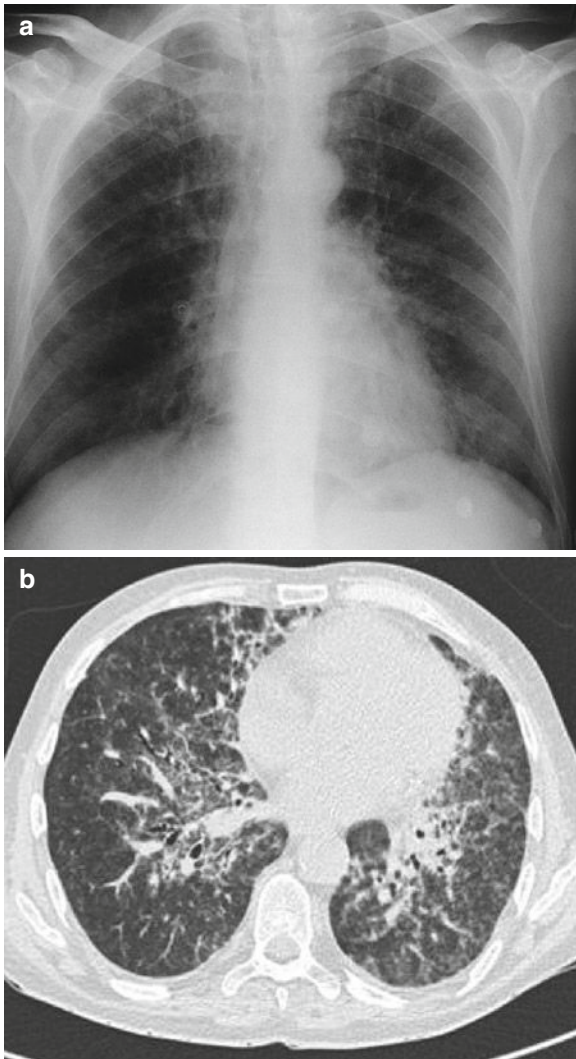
Acute respiratory failure 15 months after allogeneic stem cell transplantation for AML. Prophylaxis was withdrawn at 1 year. Chest X Ray (*panel a*) and High resolution CT scan (*panel b*) were suggestive of *pneumocystis pneumonia*. Induced sputum and BAL were negative for pneumocystis. A positive pneumocystis PCR raised concerns about the negative BAL. Re-examination (on a rescue smear) of BAL revealed trophic forms of pneumocystis
